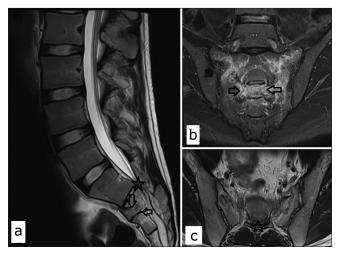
Appearance of the sacral fracture on a Magnetic Resonance Imaging scan: (a) Sagittal plane. Black arrows point to the transverse part of the fracture. A black star indicates the level of the most significant central canal stenosis. (b) Coronal plane. Black arrows point to the vertical parts of the fracture. (c) Axial plane. The black star indicates the level of the most significant central canal stenosis.
